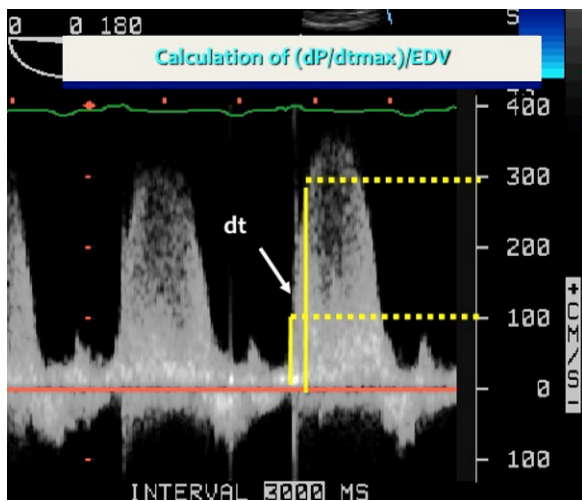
Calculation of dP/dt mean by echo-Doppler. At two different Doppler velocities, the marker is set, from which the time difference (dt) could be estimated. The modified Bernoulli equation is utilized calculating the dP . In this example, we choose 3 and 1 $m s^{-1}$, respectively: $3^2 - 1^2 / dt$
